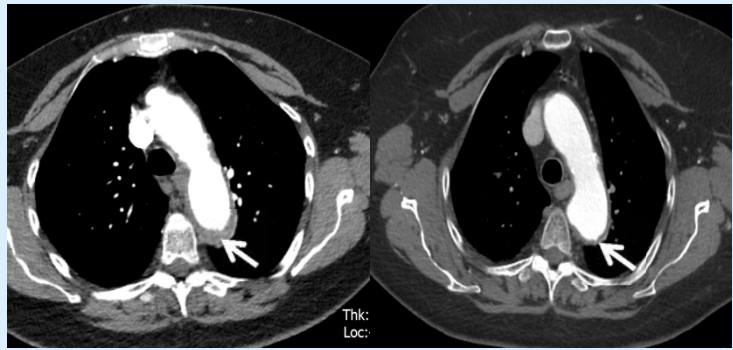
RIGHT IMAGE – CT prior to TCZ with aortic thickening (arrow), LEFT IMAGE – CT 1 year post TCZ with marked improvement.
